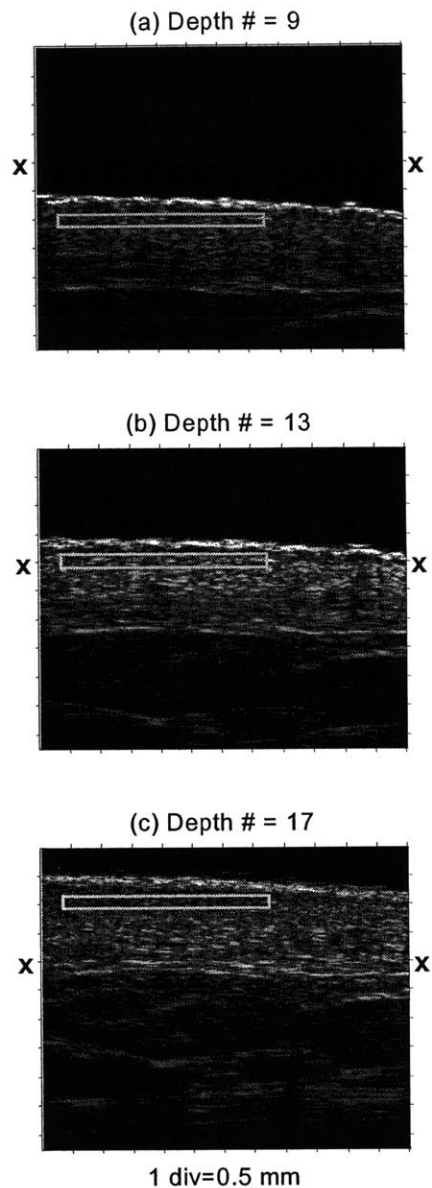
Experiments to determine diffraction correction curves. Ultrasound data were collected from skin in vivo when the tissue was at several depths separated by 0.25 mm. The figure shows three such depths, one each corresponding to the ROI being (a) below the focus, (b) at the focus and (c) above the focus. The 'x' marks indicate the location of the transducer's focal zone. The ROI drawn in the images indicate the ones used to compute mean power spectra at various distances from the transducer. Another set of ROIs, larger than the above were used to compute echo-statistics parameters.
